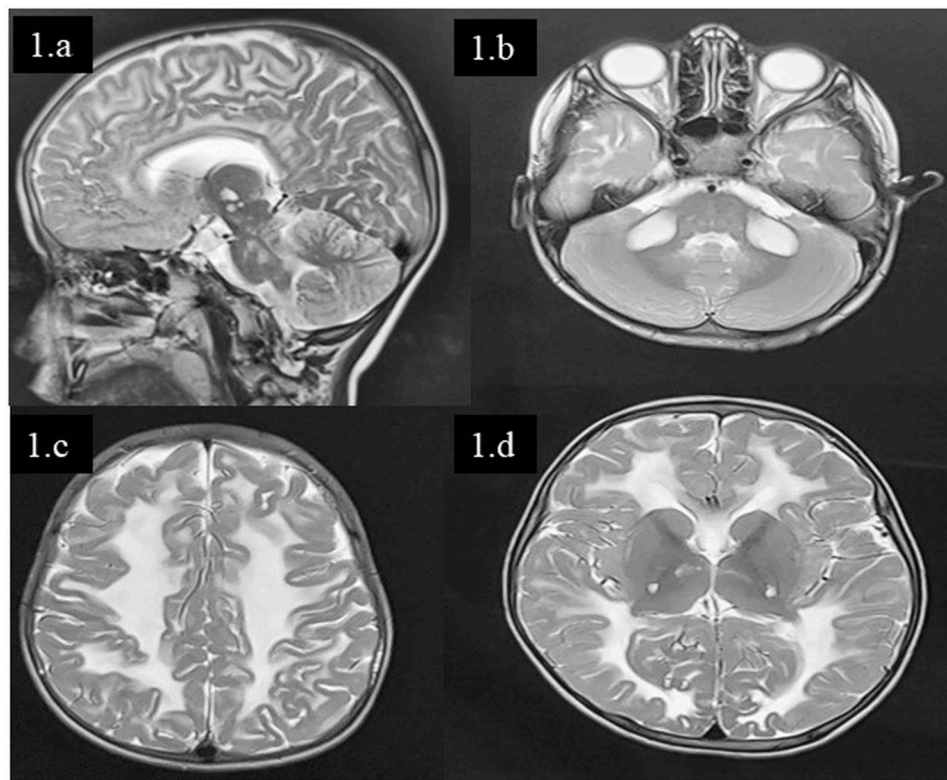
MRI Brain T2 weighted Sagittal (1a) and axial (1b-d) images of case 3 showing bilaterally symmetrical, confluent involvement of subcortical (SC), deep and periventricular (PV) white matter (WM), corpus callosum (CC), midbrain (MB), pons, thalamus, cerebellar peduncle.
